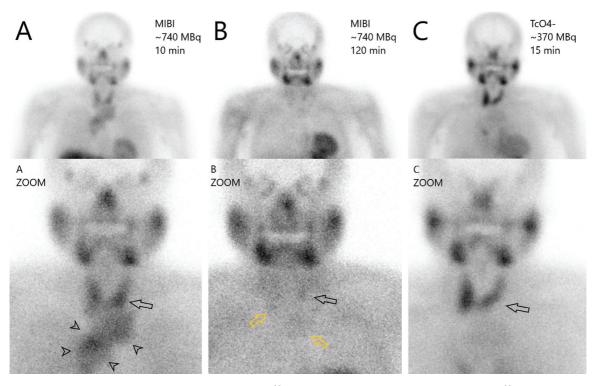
Dual-isotope planar scintigraphy with early (A) and delayed (B) 99mTc-sestamibi (methoxyisobutylisonitrile, MIBI), and 99mTc-pertechnetate (TcO<sup>4</sup>) (B) of an elderly woman undergoing evaluation for hyperparathyroidism. Early-MIBI planar scintigraphy (A) showed a large moderately-avid mediastinal lesion (arrowheads) adjacent to the thyroid gland (arrow). Delayed images (B) showed equivocal areas of minimal retention in the mediastinal mass (yellow arrows); differential diagnoses included lymphoma, thymoma, and primary intrathoracic goiter. Early-MIBI planar scintigraphy (A) also showed a relatively thicker left lower thyroid pole that was discordant with TcO4 images (C) and demonstrated minimal retention on delayed-MIBI (B), suggestive of a left lower thyroid pole localized parathyroid adenoma.
